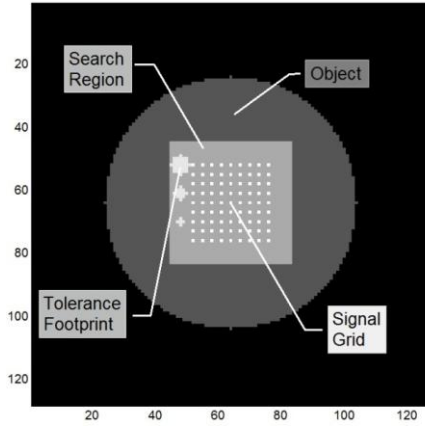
The SPECT Object (Higher Resolution)
